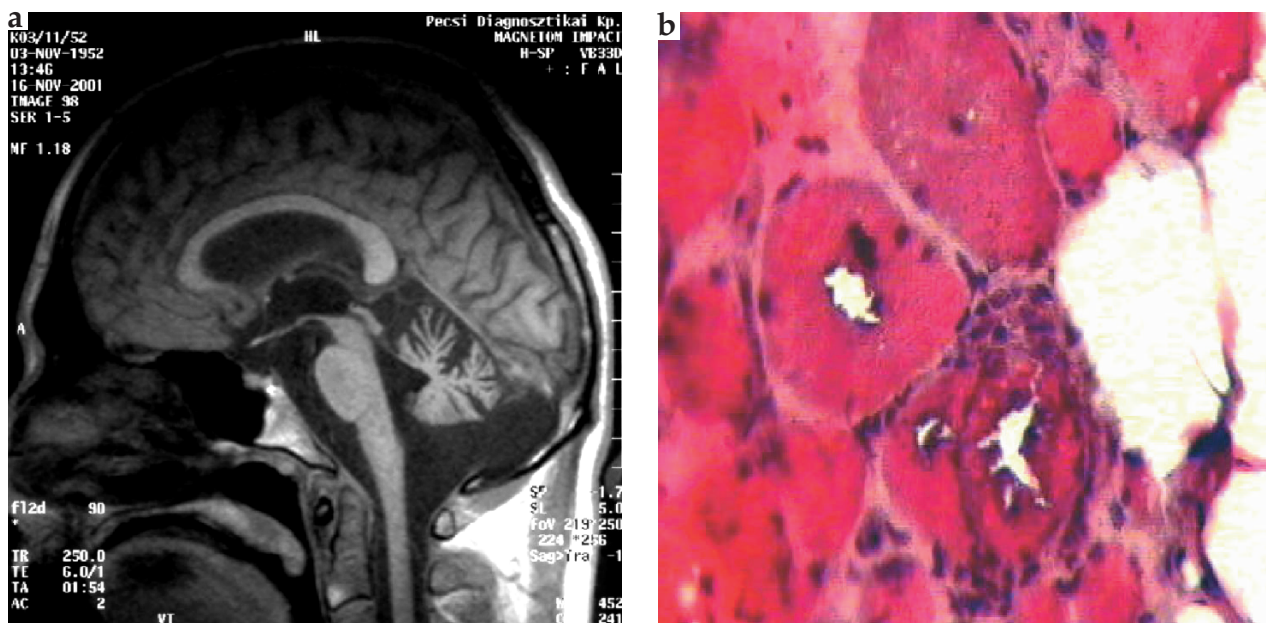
(a) Severe brainstem and cerebellar atrophy (T1-weighted brain MRI). (b) atrophic fibers and rimmed vacuole formation in the anterior tibial muscle
